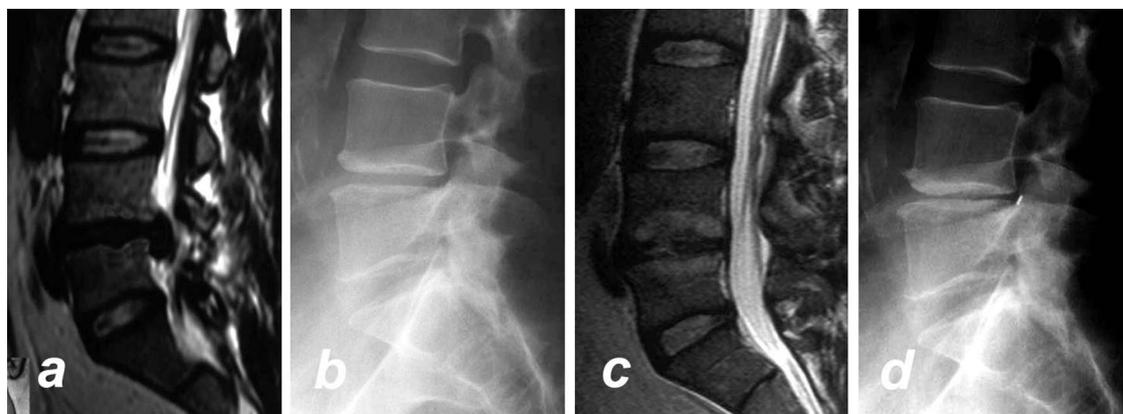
a-d, MRI and radiograph of a 49-year-old male with nucleus pulposus prolapse L4/5 and initial osteochondrosis (MODIC I) preoperative (a, b). Twenty-six months after minimal invasive nucleotomy, advanced disc degeneration is seen (c, d).
